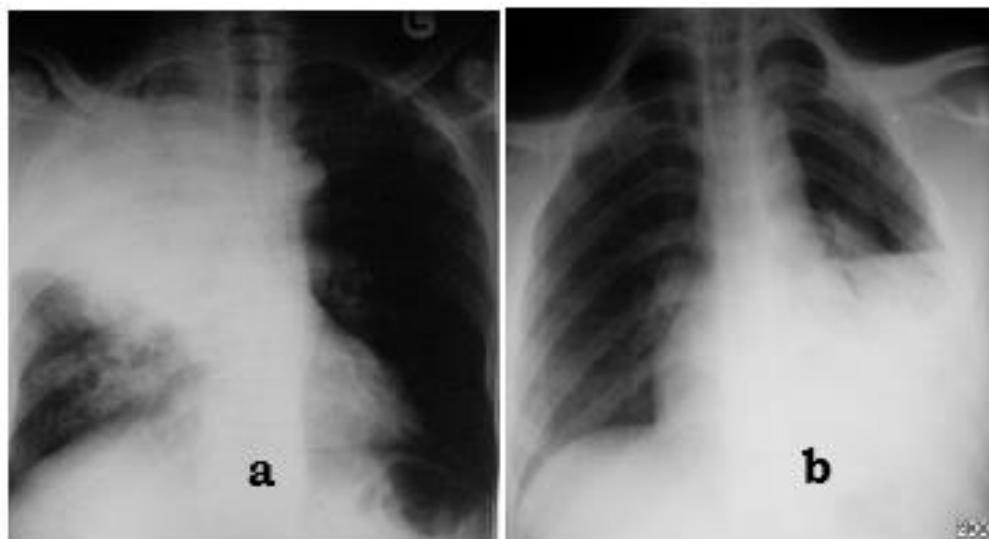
Chest radiograph in a patient with tuberculosis. a. right upper and middle lobe consolidation. b. Pleural effusion on the left hemithorax in which attempted drainage led to the formation of hydropneumothorax.
